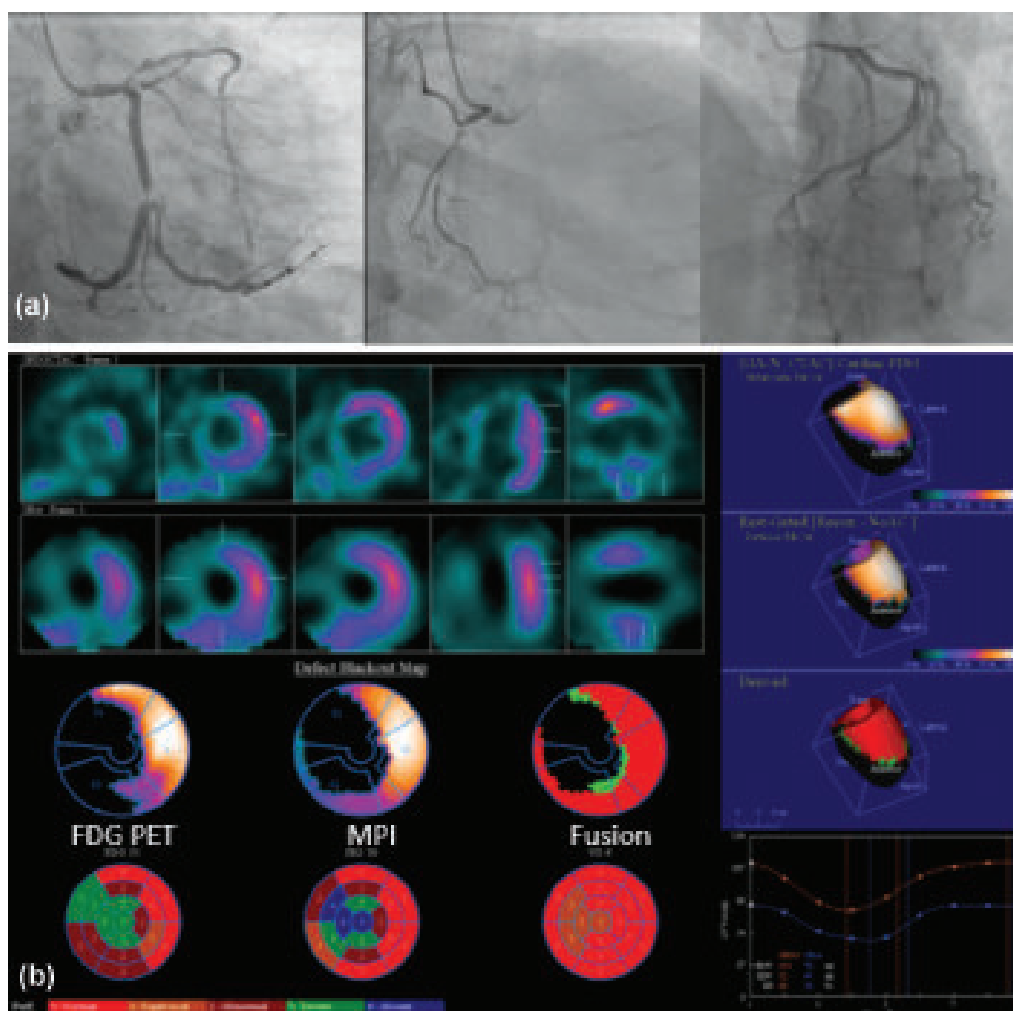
(case 2): A 53 years old male was presented with post MI angina due to old anterior MI having ICM on echocardiogram with 30% LVEF. CAG (image a) revealed triple vessel disease; LAD: 90% ostio-proximal and 80% distal stenosis, LCX: 95% bifurcating lesion involving principal OM and 95% stenosis in proximal RCA. MPI and Cardiac PET fusion imaging (image b) showed large area of perfusion & metabolism severe match defect in the apex, anterior and anteroseptal wall along the LAD territory and inferior and inferoseptal wall along the RCA territory-signify large infarct with peri-infarct ischemia. Small area of reverse mismatch (stunned myocardium) in basal inferior wall. Approximately 48% perfusion & 52% metabolic abnormality in LV myocardium in fusion image. There was dilated LV cavity, global hypokinesia and severely reduced LV global systolic function (LVEF: 32%). So, this case was not suitable for revascularization and patient underwent medical management.
